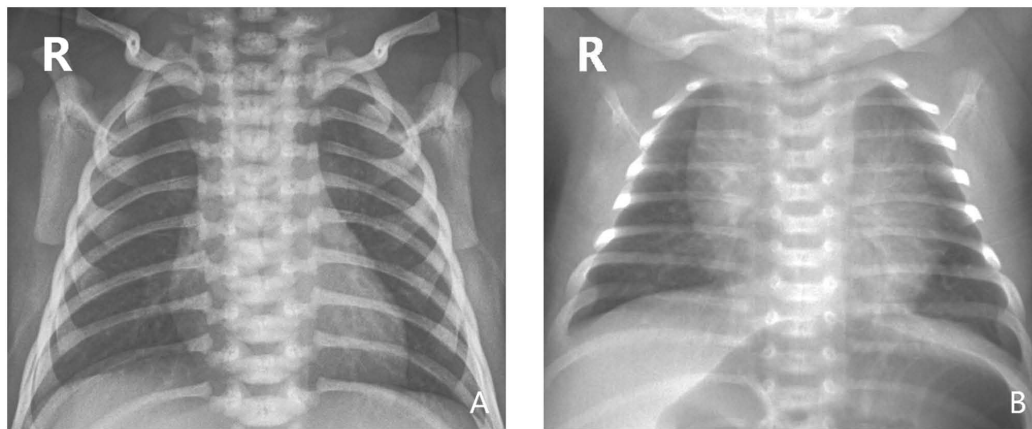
(A) Representative chest X-ray of a normal, non-infected neonate. (B) Representative chest X-ray of a neonate with RSV pneumonia, the primary manifestations of which include blurred lung texture, hyperinflation and flocculation in the middle and inner lung. RSV, Respiratory syncytial virus.
